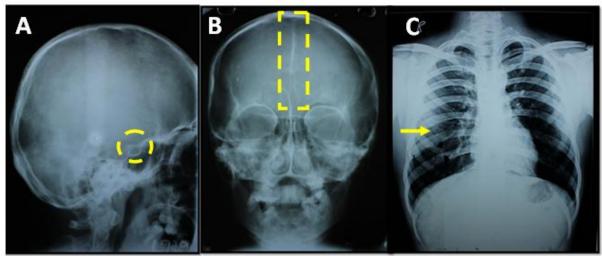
A. Lateral cephalogram showing bridging of sella turcica (circle), B. PA skull showing calcification of falx cerebri (box) and C. Chest radiograph showing bifid 4th rib on the right side (arrow).
